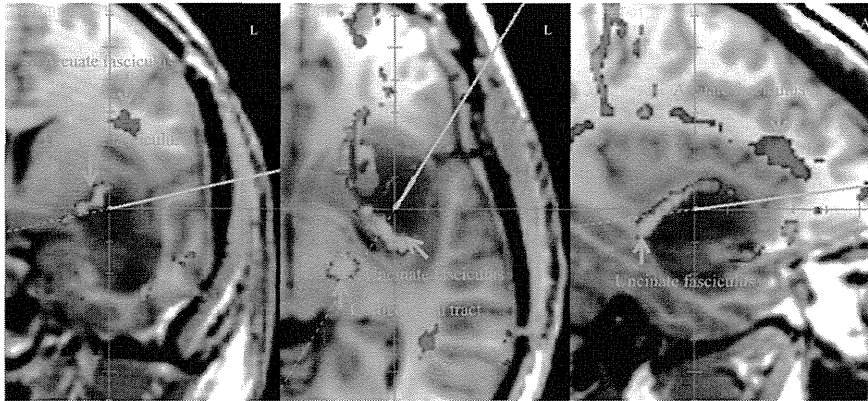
Intraoperative neuronavigation pictures, in which the preoperative two-dimensional fibre tracking was projected on transaxial T1-weighted MR images (Left: a coronal image, Middle: a transaxial image, and Right: A sagittal image). The blue lines point to where the electrical stimulation with a picture-naming task was provided. L: left, A: anterior.
